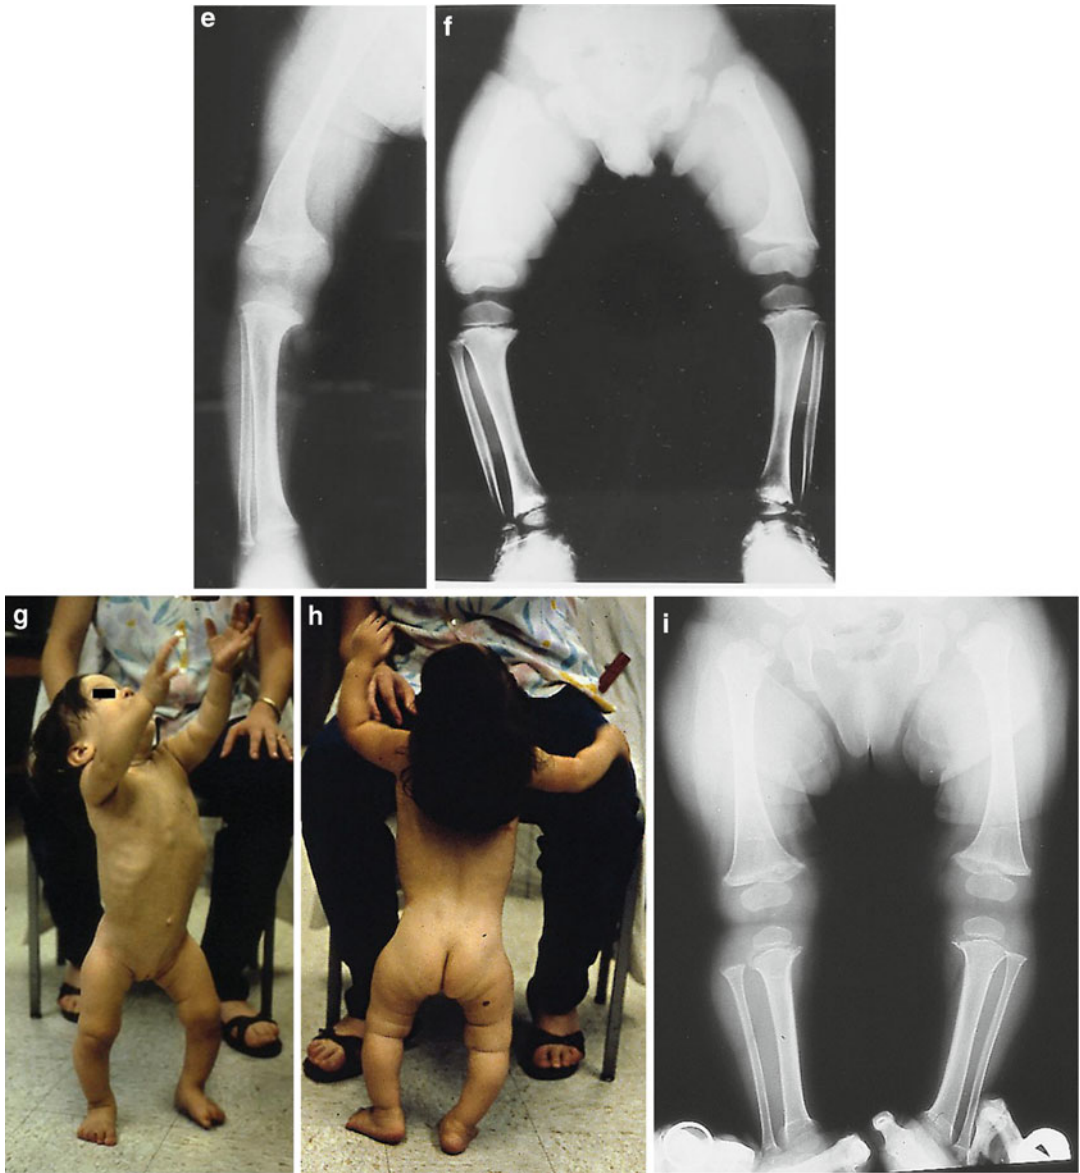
(a–i) Three young children (a, b; c, d; g, h) with Schmid metaphyseal chondrodysplasia showing short stature, lumbar lordosis, and bowing of the legs. Radiographs (e, f, i) showed genu varum and metaphyseal widening with fraying and cupping. Epiphyses are normal
